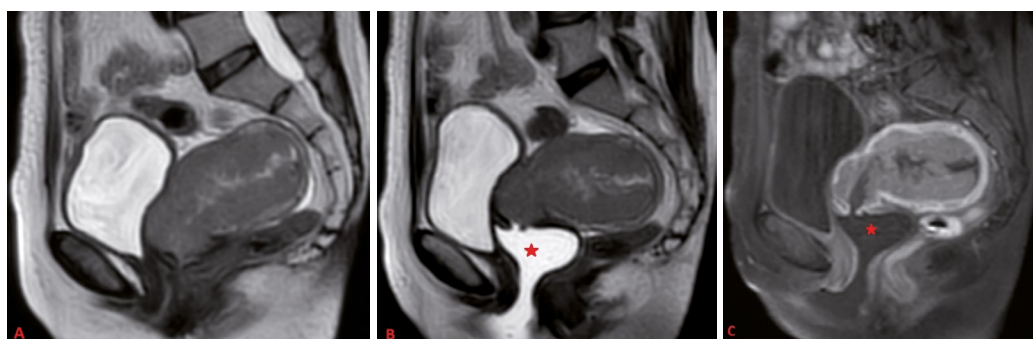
Endometrial cancer. Before vaginal gel (A), after vaginal gel (B) sagittal T2W and after vaginal gel with post-contrast sagittal T1W MRI (C). Vaginal and cervical anatomical structures and cervical extension of endometrial cancer can be seen more clearly in after gel images (asteriks: vaginal ultrasound gel)
